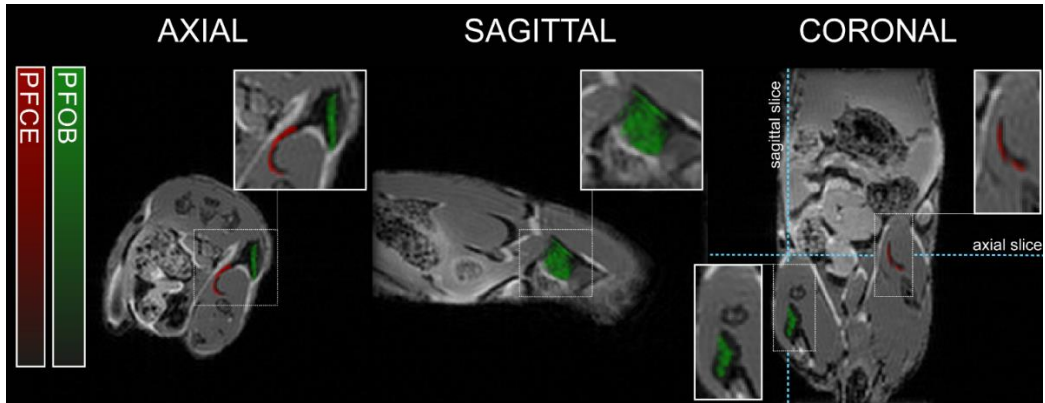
^{19}F -MRI after intramuscular injections of PFOB and PFCE nanoemulsions. Reconstructed PFOB (green) and PFCE (red) signals (arbitrary units) are overlaid on the ^1H -MRI anatomical image. PFOB was injected on both sides and PFCE in the right upper leg only.
